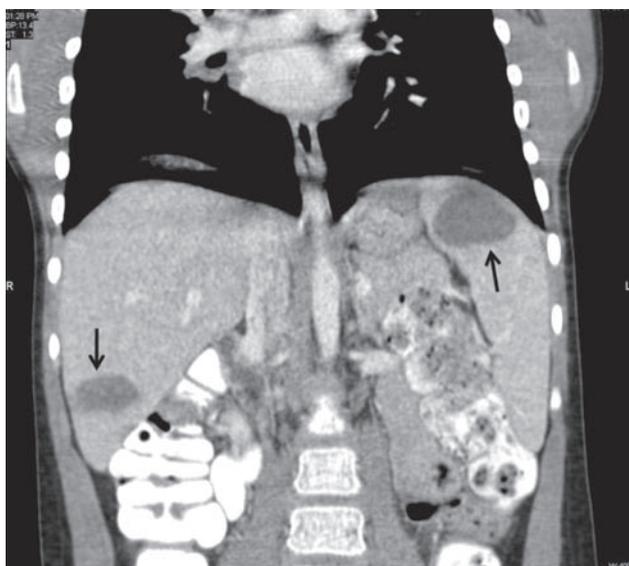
Contrast enhanced CT coronal reformatted image shows hepatic and splenic hydatid cysts (arrows).
